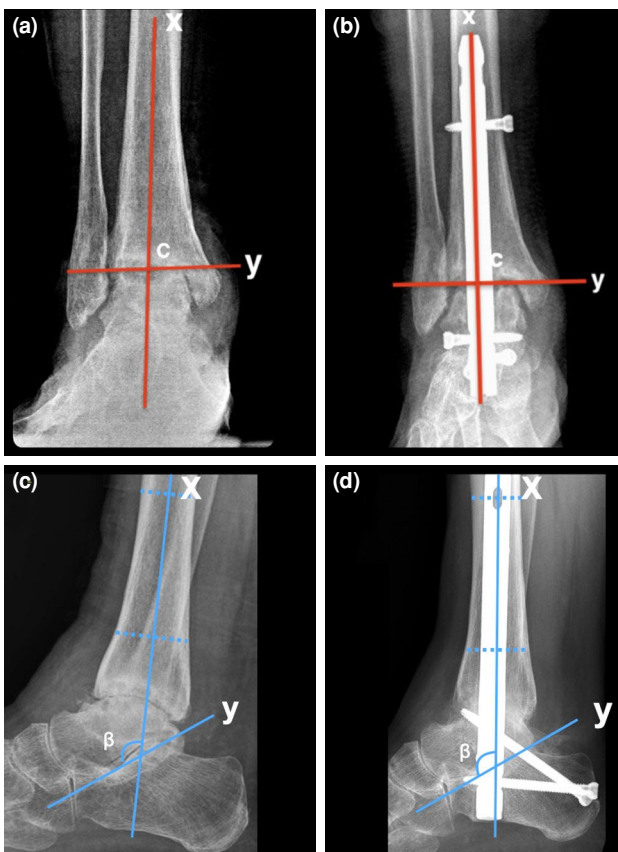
Coronal tibiotalar (CTT) angle measurements on preoperative (a) and postoperative (b) ankle radiographs. In both radiographs, this was done by measuring the superomedial angle (c), formed by the long axis of the tibia (x) and the line defining the talar shoulders (y). The obtained angle was used to determine coronal alignment, which was defined as the CTT angle. Sagittal tibiotalar (STT) angle measurements on preoperative (c) and postoperative (d) ankle radiographs. In both radiographs, this was done by measuring the angle between the two axes, formed by the long axis of the tibia, created by connecting two points in the middle of the proximal and the distal tibial shaft (x) and the line defining the axis of the talus, defined by a line drawn from the inferior aspect of the posterior tubercle of the talus to the most inferior aspect of the talar neck (y). The obtained angle was used to determine sagittal alignment, which was defined as the STT angle.
